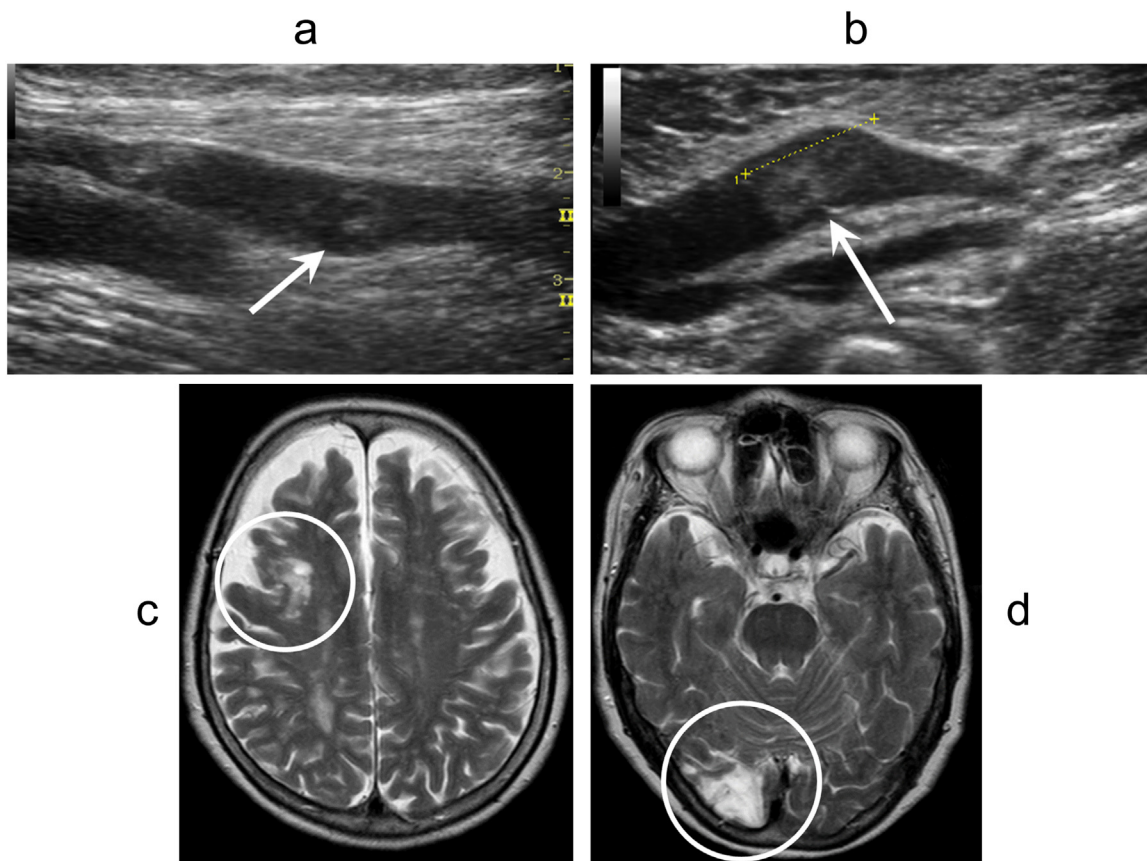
Images of repeated thromboembolic events. Venous ultrasonography of lower extremities indicates an extensive fresh thrombus in the middle portion of the left superficial femoral vein (a) and a 13-mm thrombotic occlusion in the right popliteal vein (b). T2-weighted brain magnetic resonance imaging shows areas of cystic degeneration and atrophic changes are seen in the right frontal lobe (c) and right occipital lobe (d). These were thought to be associated with old cerebral infarctions.
